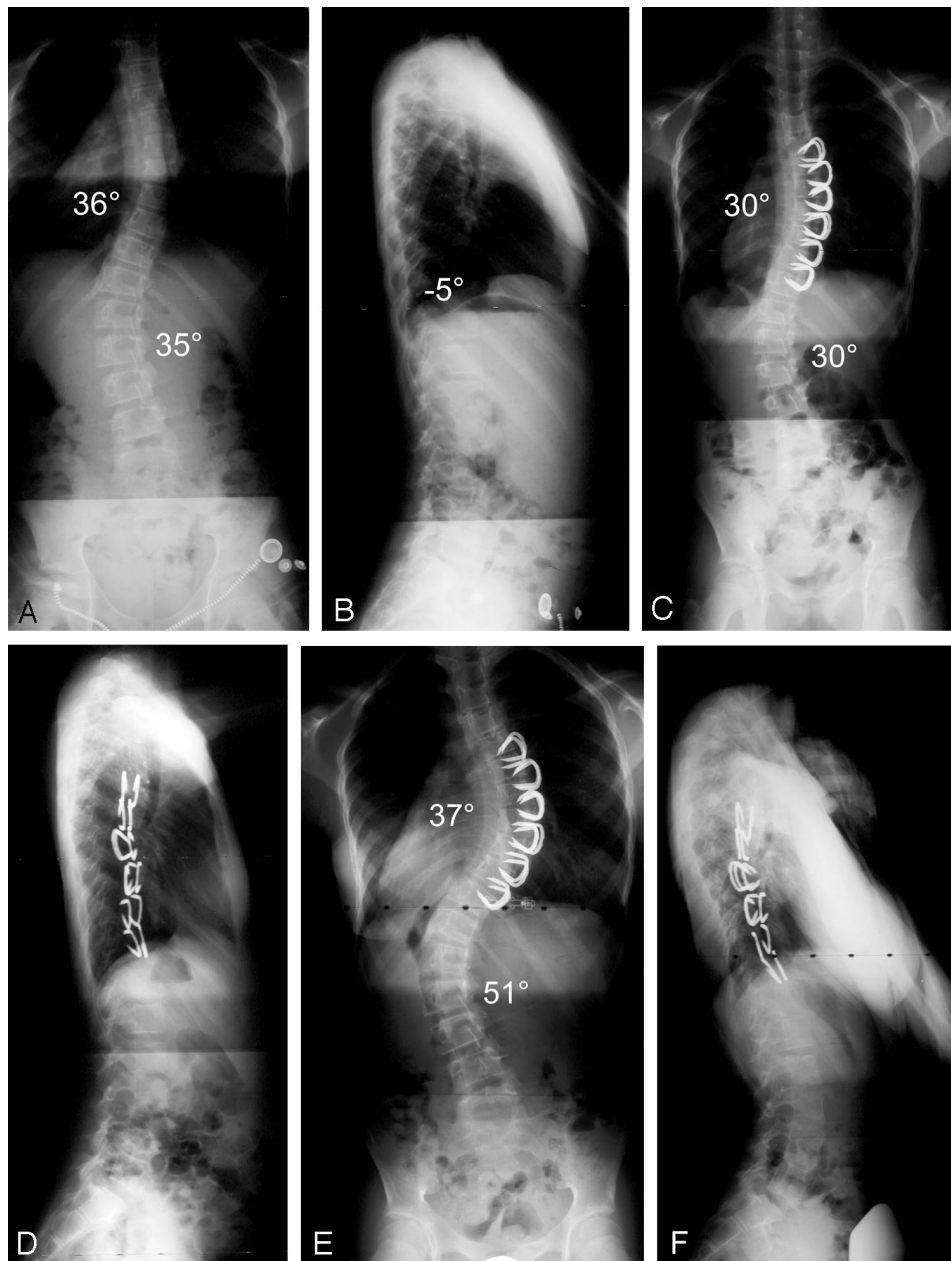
Case 4. This is a 10-year-old female who presents with idiopathic scoliosis. Magnetic resonance imaging is normal. She has open triradiate epiphyses and is premenarche. On the posteroanterior film (A), her scoliosis measures 36° thoracic, 35° lumbar, and on the lateral (B) her kyphosis from T5 to T12 is -5°. The patient underwent vertebral body stapling from T5 to T11. The initial erect postoperative film (C) shows the scoliosis to measure 30° thoracic, 30° lumbar. The lateral radiograph (D) shows two staples at each interspace. By the time the patient was 2 years poststapling, her lumbar curve (E) had increased to 51°. The thoracic curve (F) was still stable at 37°. The patient had a significant cosmetic deformity with trunk shift and asymmetrical hips. A fusion was recommended because of the progression in the lumbar curve, the fact that she was still premenarche, and she refused to wear a brace. G, This is the immediate anteroposterior prefusion film which is 2.5 years poststapling. The thoracic curve now has increased to 55° and the lumbar to 67°. Without control of the lumbar curve, the thoracic curve may have had to increase.⁴⁶ Preoperative left (H) and right (I) bend films. The left bend film shows the scoliosis to increase no further than what it does in the erect position, suggesting a successful tether on the convexity from the staples. However, on the right supine bend film, the scoliosis reduces to 33°, suggesting preserved motion. Postoperative anteroposterior (J) and lateral erect (K) films show excellent correction in both the coronal and sagittal planes. There was no restriction of motion on distraction between the spinous processes, and the staples do not appear to have inhibited the postoperative correction.
